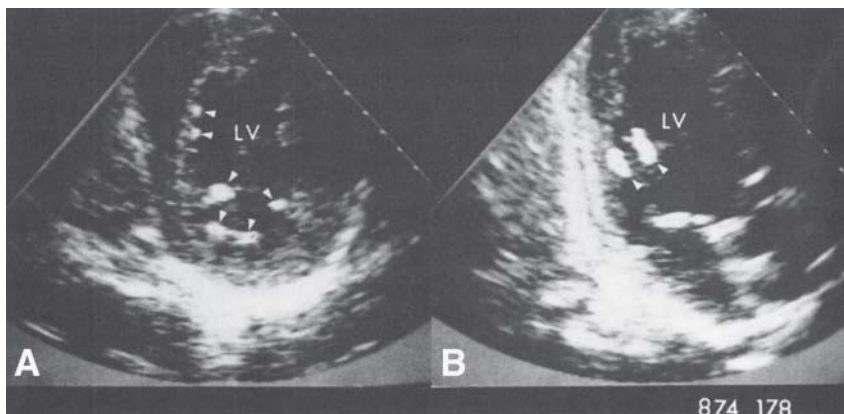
Short-axis (A) and apical two chamber (B) two-dimensional echocardiograms of a patient with endomyocardial disease and eosinophilia. Numerous echogenic area (arrowheads) can be seen throughout the left ventricular endocardium. LV, left ventricle. From Feigenbaum H. Echocardiography. Fourth edition. Philadelphia, PA: Lea & Febiger, 1986:539. Reprinted with permission.
